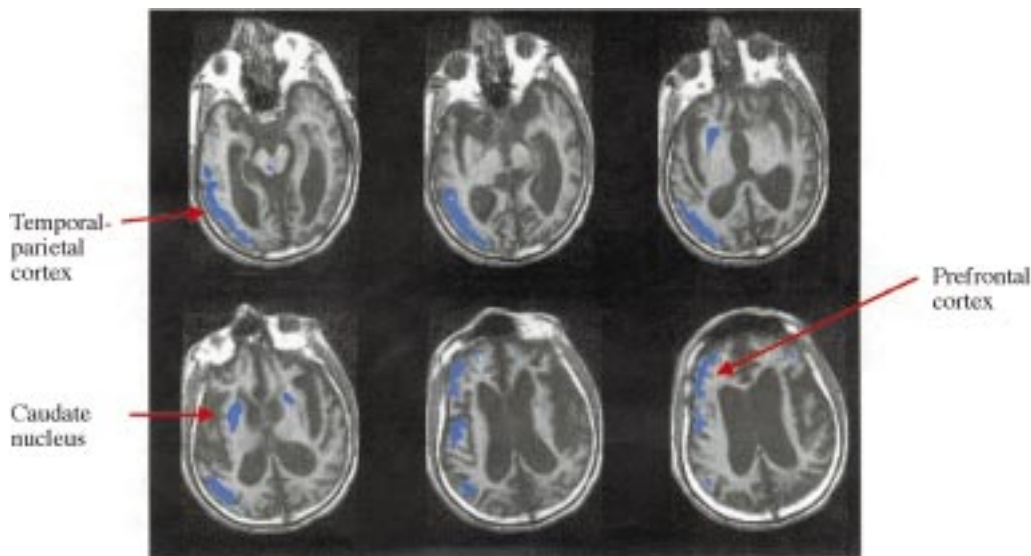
FDG-PET regions of interest for patient 3 are displayed in blue on coregistered MRIs. All areas express  $>30\%$  and a maximum of  $40\%$  of normal metabolism, remaining brain regions demonstrate  $<30\%$  of normal metabolism. Regions of higher metabolism include the temporal-parietal and prefrontal cortices of the right hemisphere and the anterior basal ganglia. Note the marked atrophy of the brain on the MRI image as indicated by the dilation of the third and lateral ventricles, and widening of cortical sulci.
